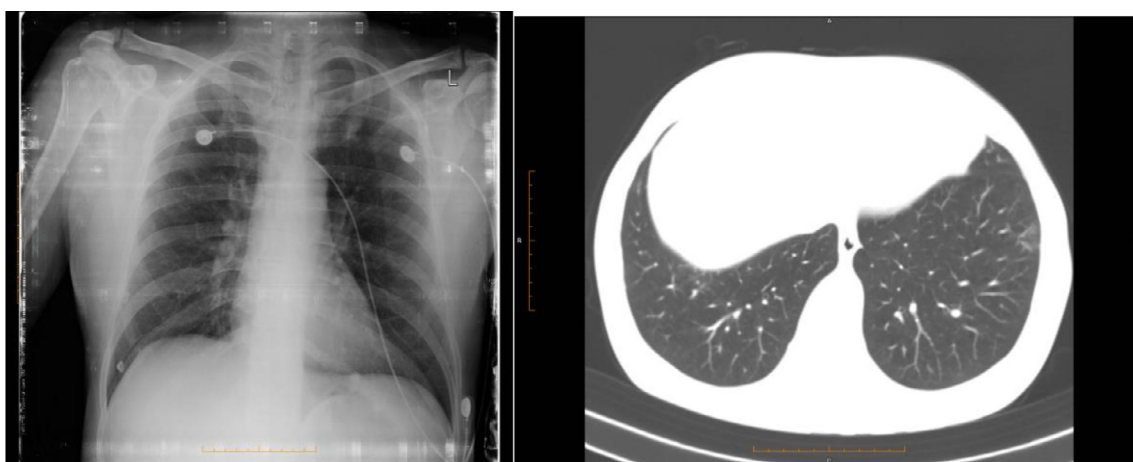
Chest X-ray shows no signs of pulmonary involvement. Chest CT, 2 weeks after COVID infection, shows mild ground-glass opacities with peripheral distribution (yellow arrow), CTSS 2/25 points.
